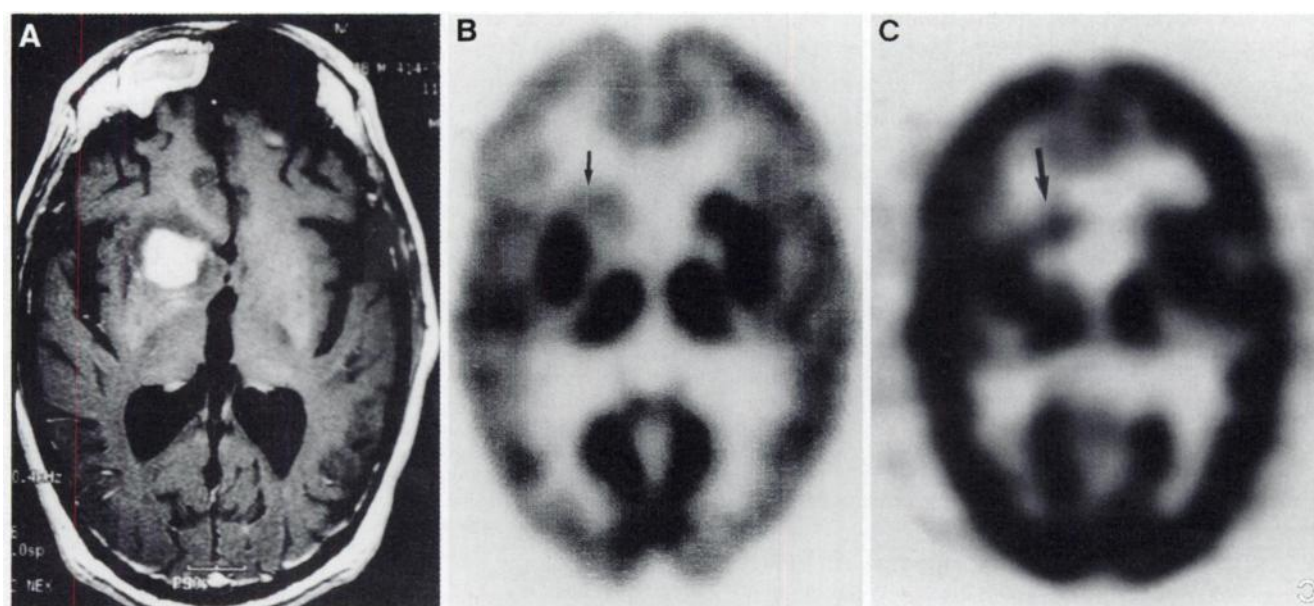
49-y-old HIV-positive man presented with change in mental status accompanied by sinusitis. Gadolinium-enhanced T₁-weighted MR image (A) shows enhancing lesion in head of right caudate nucleus. Both PET (B) and DHC (C) images show decreased uptake in same location, indicating toxoplasmosis rather than lymphoma (patient Y, arrows).
